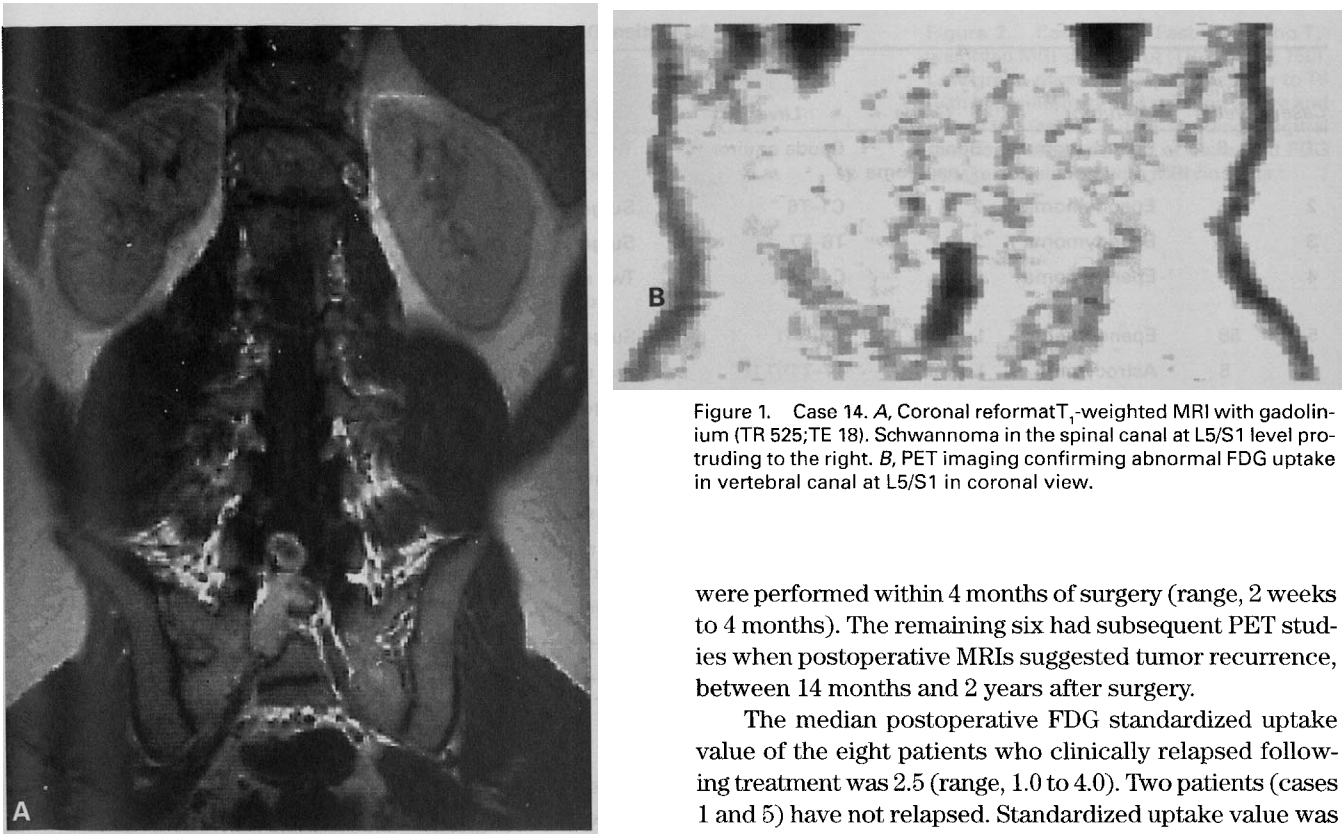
Case 14. A, Coronal reformat T₁-weighted MRI with gadolinium (TR 525; TE 18). Schwannoma in the spinal canal at L5/S1 level protruding to the right. B, PET imaging confirming abnormal FDG uptake in vertebral canal at L5/S1 in coronal view.
